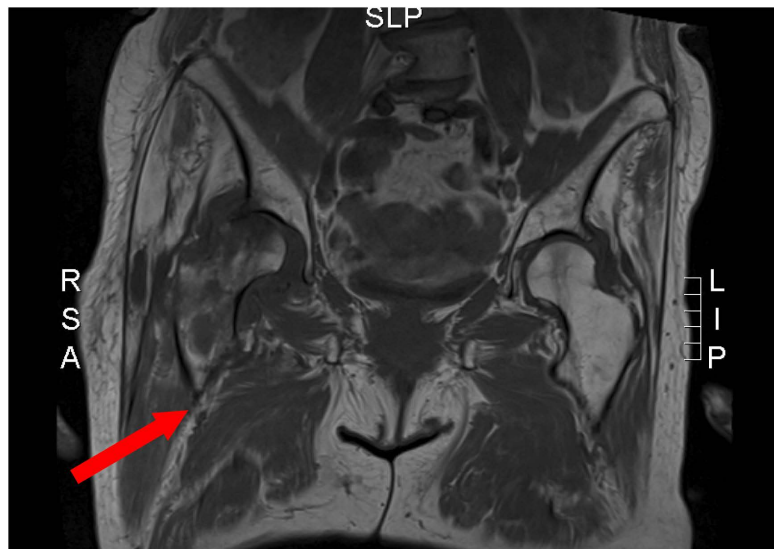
MRI of the hip, T1 images.
